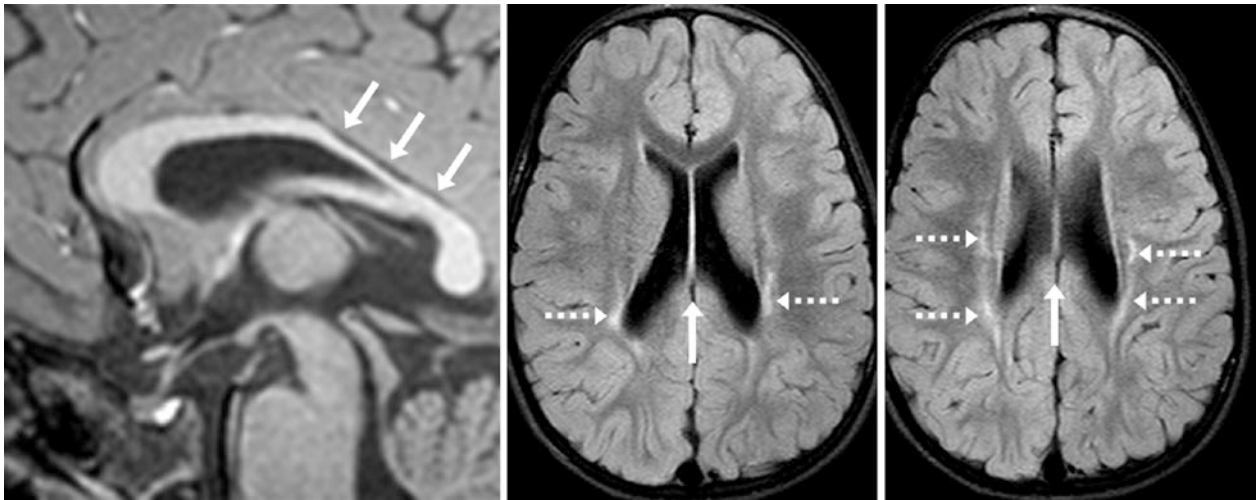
Comparison case of atrophy from perinatal ischemia. A 3 year old born prematurely at 29 weeks' gestational age subsequently developed a spastic gait disorder. A 3T MRI depicted severe, focal atrophy of the posterior callosal body and isthmus (arrows) on sagittal
